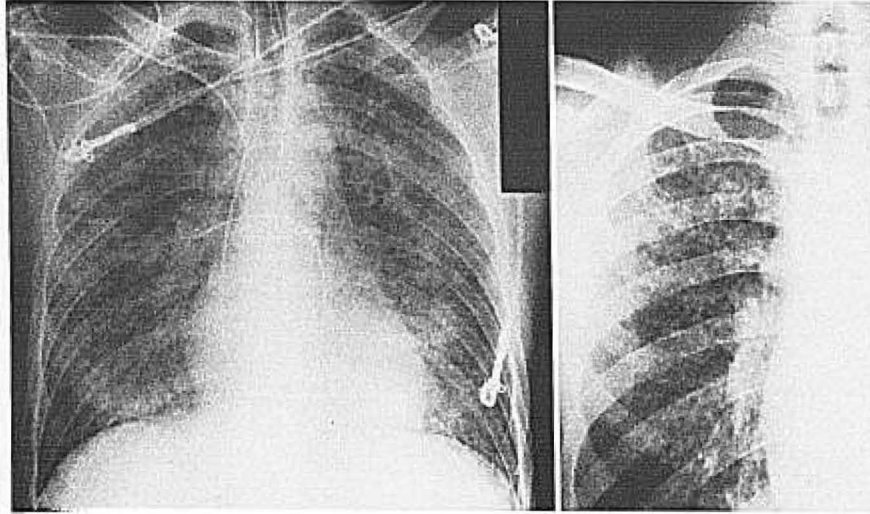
Varicella pneumonia. The chest radiograph on the left is from the case report described in the protocol. The close-up film on the right in another patient shows peribronchovascular infiltrates and multiple 1–4-mm rounded opacities in the right lung field.
